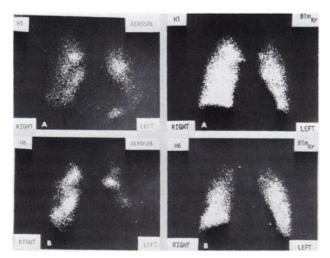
Anterior radioaerosol and Kr-81m scintigrams for a nonsmoker (A) and an asymptomatic smoker (B), taken from healthy subjects used in this study (H1 and H6, Table 1.). Radioaerosol images contain approximately 100,000 counts collected over a fixed period of 10 min. Both images were taken 10 min after inhalation. Kr-81m images contain 400,000 counts and were obtained after a 30-sec equilibration period.
